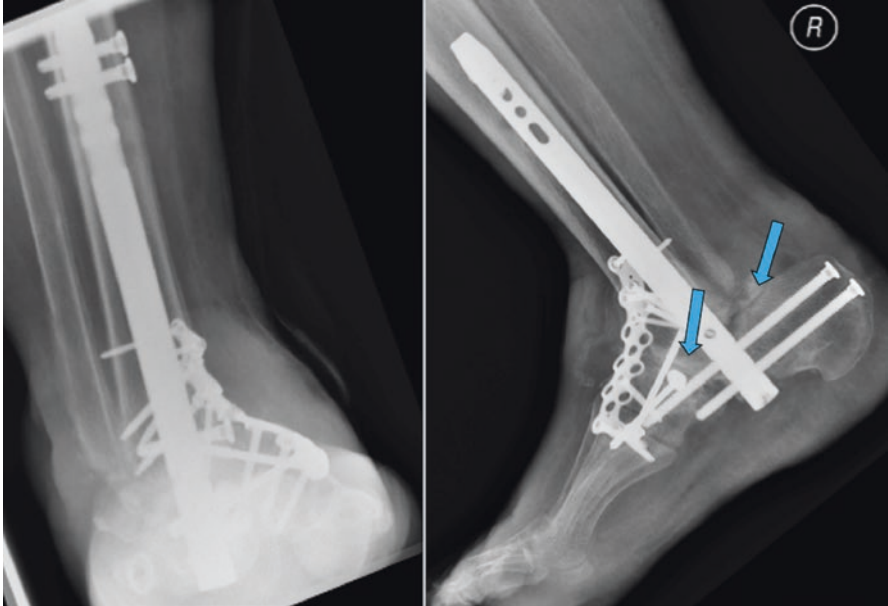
Post-operative AP and lateral radiographs of foot and ankle showing the internal fixation construct has provided good deformity correction, secure fixation and optimal bone opposition. Injectable antibiotic eluding calcium sulphate and hydroxyapatite preparation (arrows) is used to fill in the bone voids
